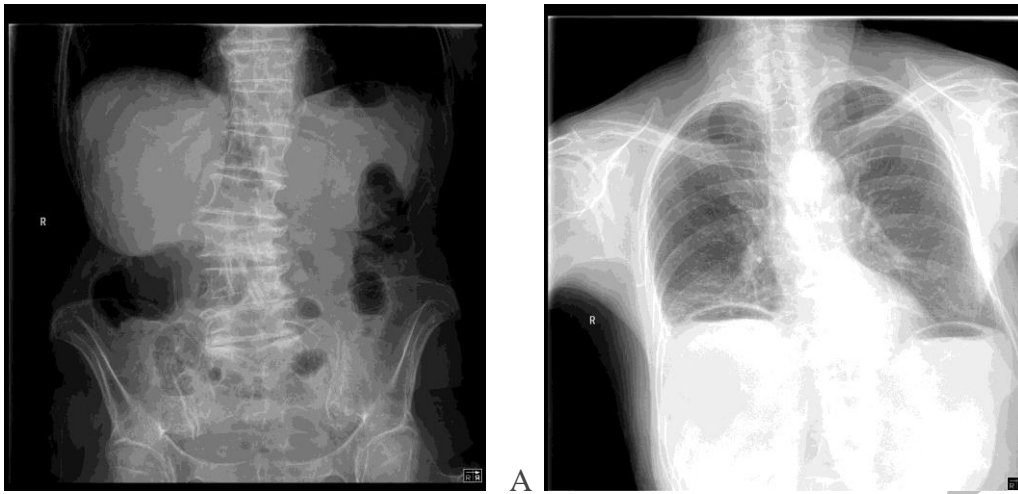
Abdominal (A) and chest (B) X-ray
